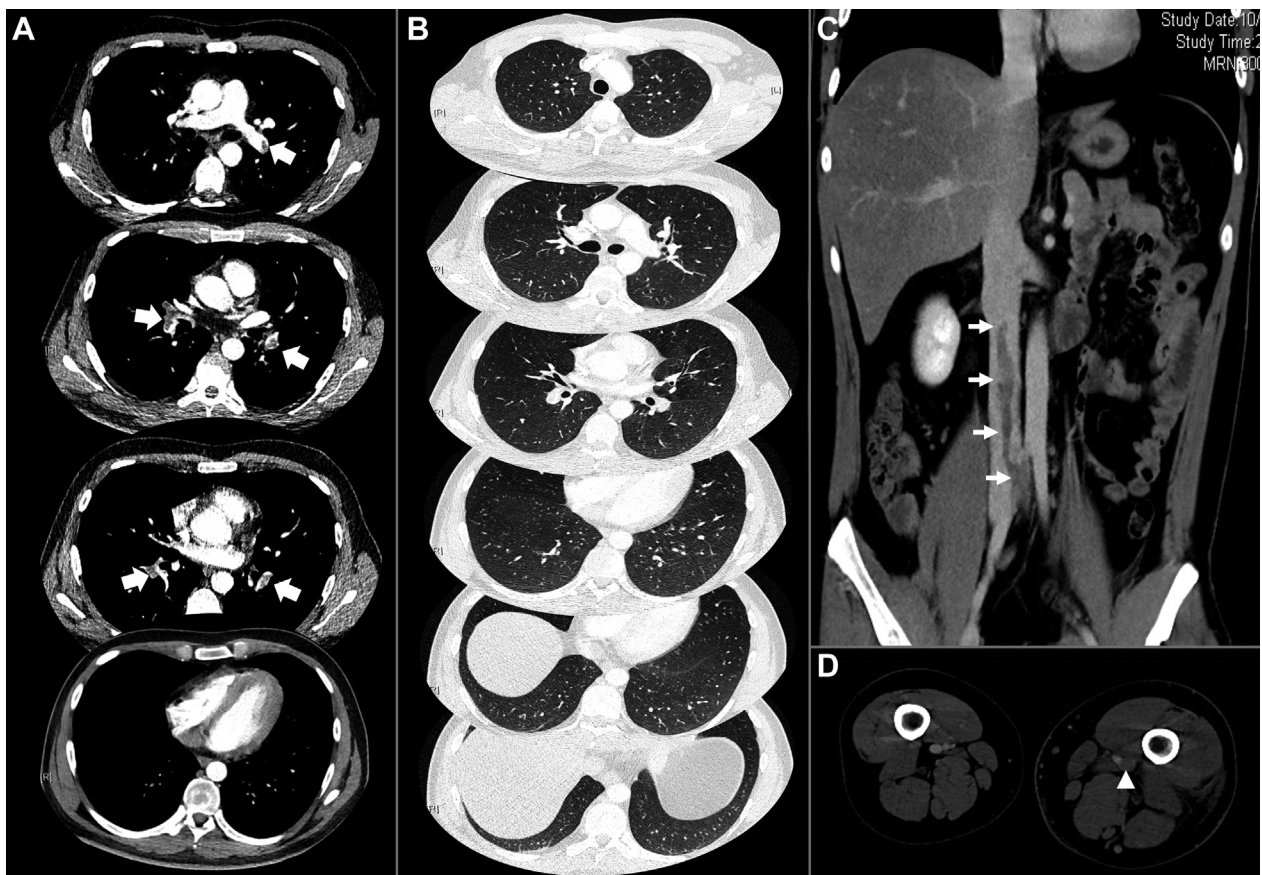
A-D, CT pulmonary angiography and venography showing multiple troncular, lobar, and segmental thrombi (arrows) (A); normal lung parenchyma (B); extensive thrombus of the lower vena cava (arrows) (C); and enlargement of the left leg with femoral venous thrombosis (arrowhead) (D).
